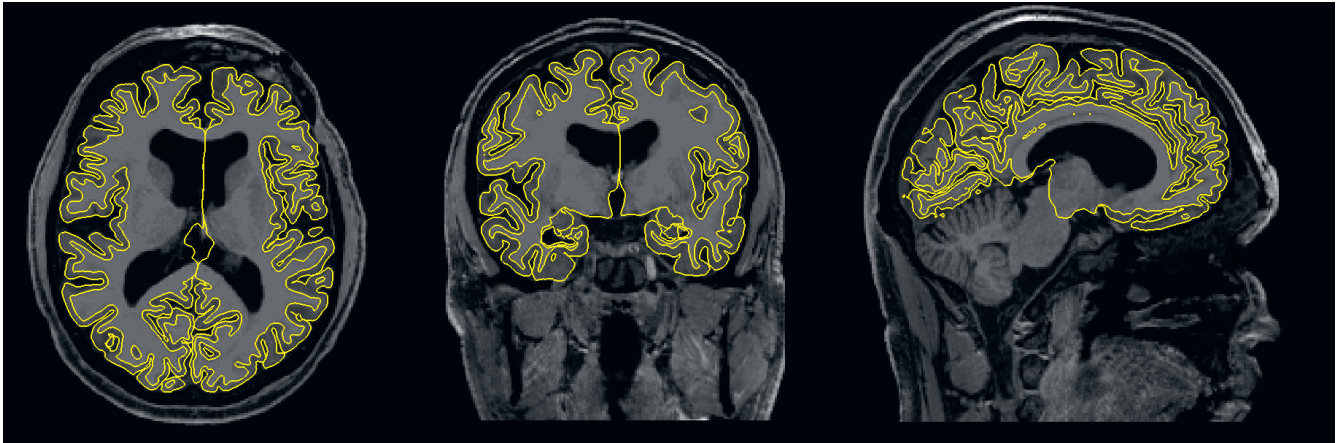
Cortical thickness borders overlaid on an anatomical T1-weighted Freesurfer image
